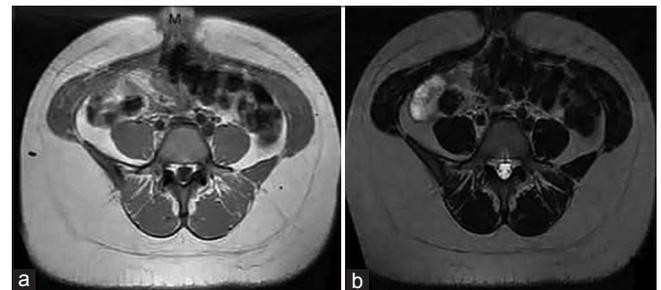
Axial T1-weighted (a) and T2-weighted (b) Magnetic resonance images at the level of the umbilicus showing an oval umbilical mass (M) representing umbilical endometriosis demonstrating heterogeneous intensity on both T1W and T2W images
